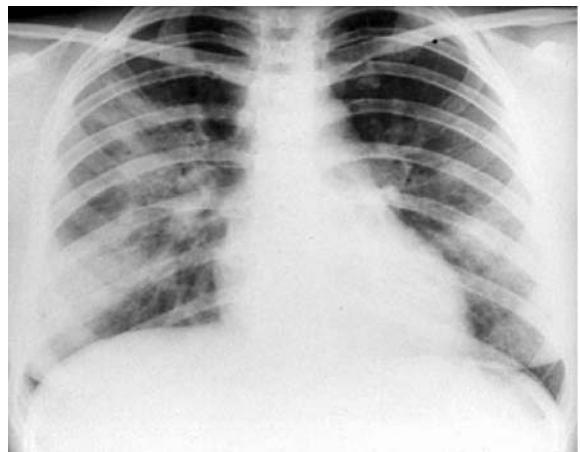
Churg–Strauss syndrome: chest radiograph showing transient pulmonary infiltrates.
